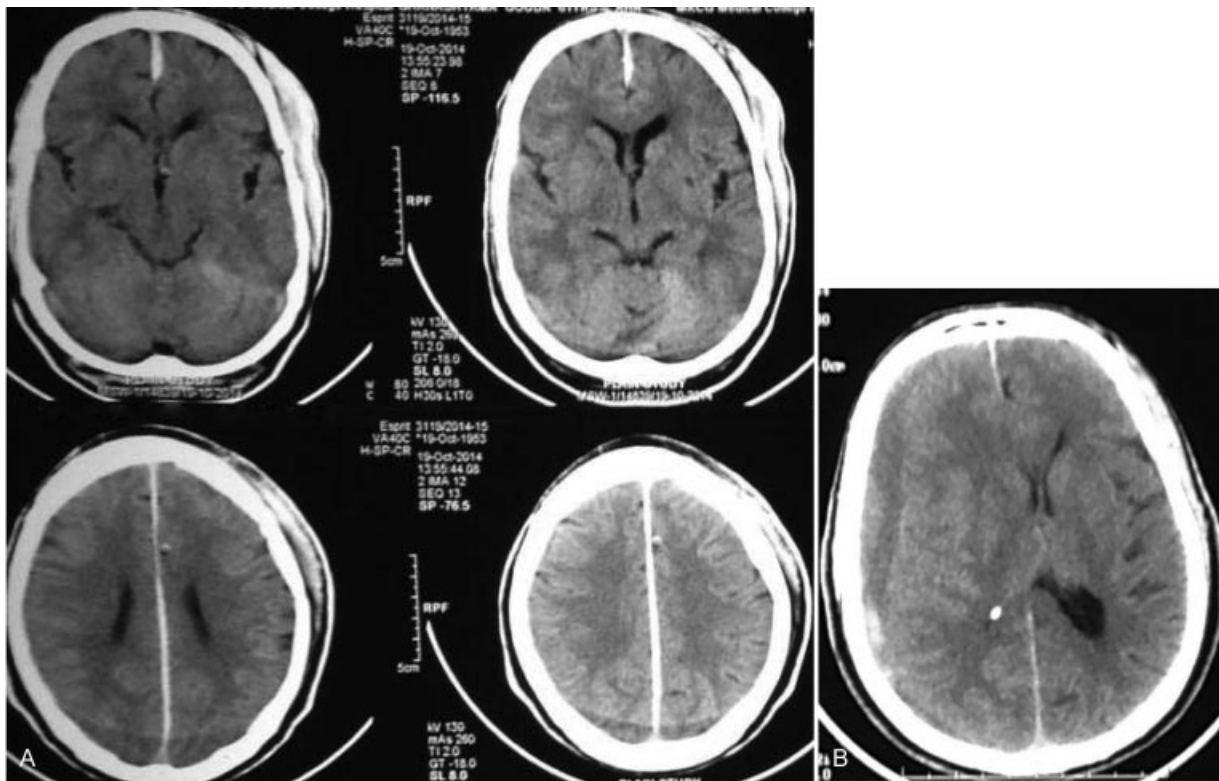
(A) Initial CT of the head showing inter-hemispheric hematoma. (B) Follow-up CT of the head showing development of right chronic subdural hematoma with significant midline shift. CT, computed tomography.
